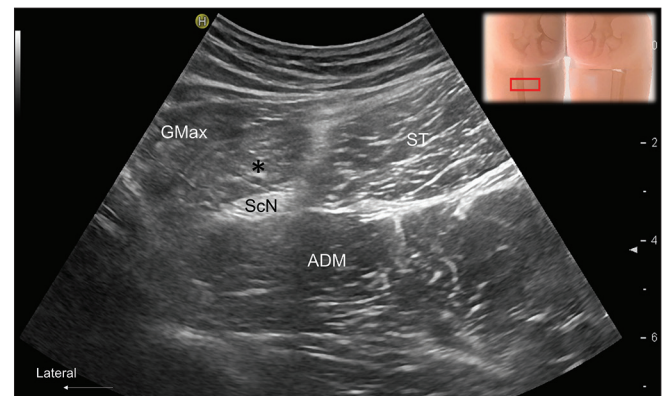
Ultrasound images over the proximal posterior thigh at the contra-lateral asymptomatic site at the short-axis view. ST: Semitendinosus, GMax: Gluteus maximus, ADM: Adductor magnus; black asterisk, long head of the biceps femoris
